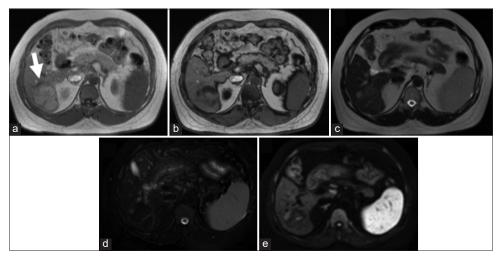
A 46-year-old male presented with hepatocellular carcinoma presenting with passing black tarry stool for 3 months. (a and b) T1 chemical shift abdominal MRI showed a hyperintense mass (white arrow) during inphase (a) along with signal loss during opposed-phase (b). (c) Hyperintense component was seen on T2-weighted sequence. (d) The mass appeared to be suppressed during T2 fat saturation technique. (e) On DWI sequence, part of the mass appeared with pathologic diffusion restriction.
